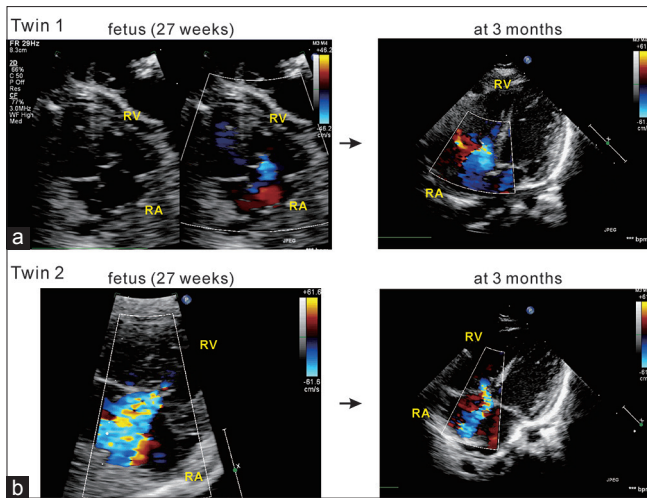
Changes in tricuspid regurgitation severity before and after birth. Left panels showing fetal echocardiograms at 27 weeks and 6 days, and right panels showing echocardiograms at 3 months after birth. (a) In Twin 1, the donor in twin amniotic fluid discordance circulation, severity of tricuspid regurgitation worsened after birth (from “mild” to “moderate”). (b) In Twin 2, the recipient of twin amniotic fluid discordance circulation, severity of tricuspid regurgitation was ameliorated after birth (from “moderate to severe” to “moderate”)
